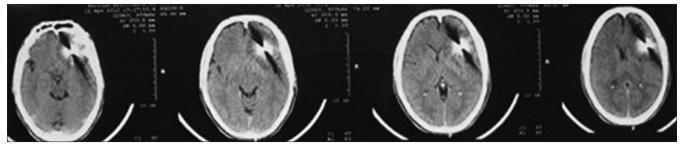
Head axial CT images in parenchyma window showing the rifle rod penetrating from inferior to superior through the skull base to the left frontal lobe with a metallic artifact.
